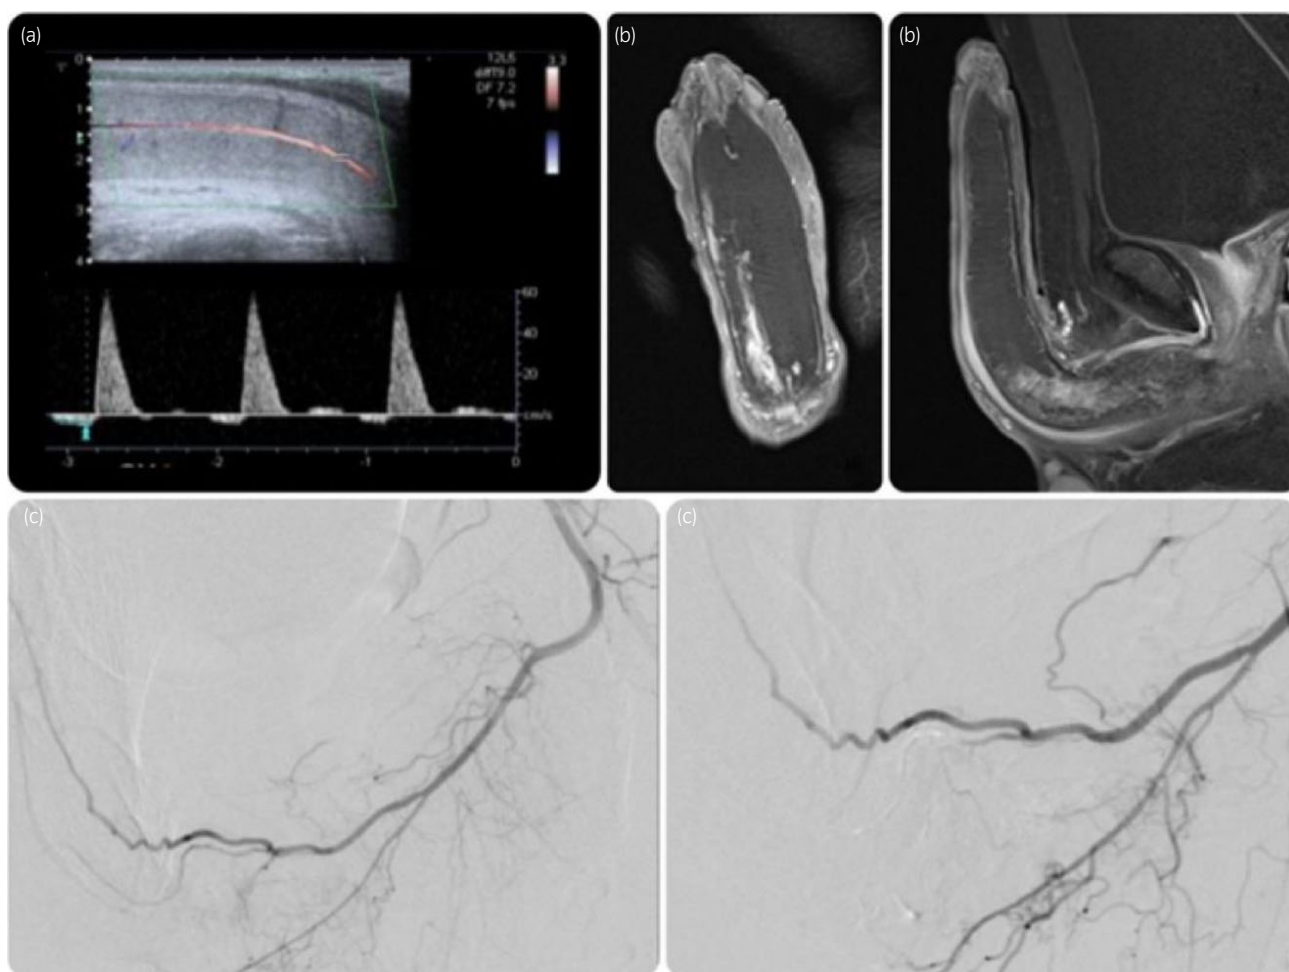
(a) Color Doppler US revealing high-velocity flow (61 cm/s) in the right cavernosal artery at priapism recurrence; (b) MRI of the penis after gadolinium administration at priapism recurrence; (c) before and after super selective embolization of the left cavernosal trunk.
